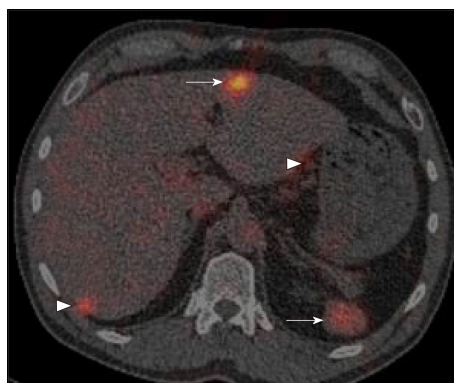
Denatured red cell scan with fused computed tomography images. The liver lesion (thick arrow), peritoneal and retroperitoneal nodules (arrowheads) and spleen (thin arrow) show uptake in keeping with multiple areas of splenic tissue.
